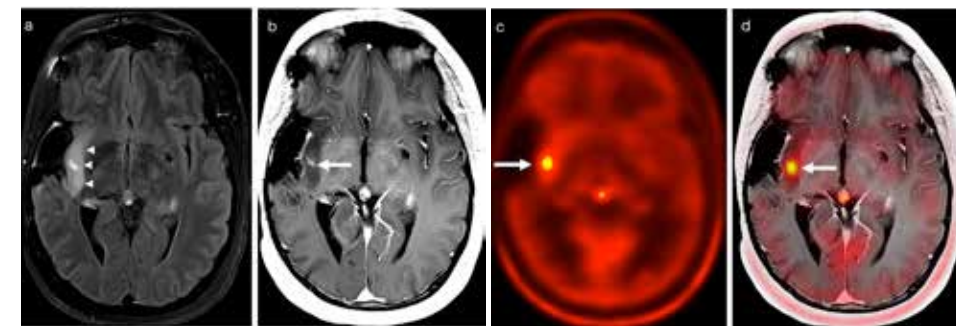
A signal from an anaplastic astrocytoma remained stable for 8 years after surgery. Image B: The tumor developed a small focus of enhancement that was not conclusive using MRI. Image C/D: However, [¹¹C]-Methionine position emission tomography showed a clear focus that indicated tumor progression.
